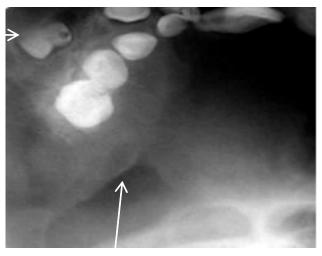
Maxillary occlusal radiograph showing cortical expansion with radiopaque internal mass & buccal displacement of 12,13,14 (arrows).
